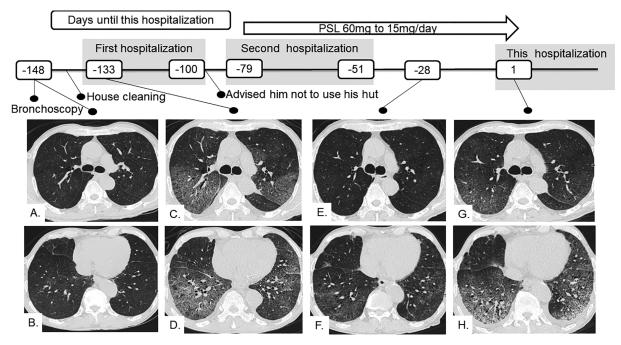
Chest computed tomography (CT) over the clinical course of the patient's disease. Figures A, C, E and G are cross-sectional CT images at the level of the carina trachea. Figures B, D, F and H are cross-sectional CT images at the level of the diaphragm. Figures A and B are CT images taken on June 3 (148 days prior to the admission). A:CT image showing segmental ground-glass opacities (GGO) in both upper lobes; B:CT image showing GGO in both lower lobes. Figures C and D are CT images taken on August 11 (79 days prior to the admission). C:CT image showing increased concentrations of GGO in the dorsal upper lobes of both lungs; D:CT image showing posterior consolidation with air bronchograms in the posterior segments of the lower lobes of both lungs. Figures E and F are CT images taken on October 1 (28 days prior to this admission). E:CT image showing disappearance of the GGO in the upper lobes of both lungs; F:CT image showing disappearance of the GGO in the lower lobes of both lungs. Figures G and H are CT images taken on October 29 (hospital day 1). G:CT image showing worsening of the GGO in both upper lobes of the lungs.
